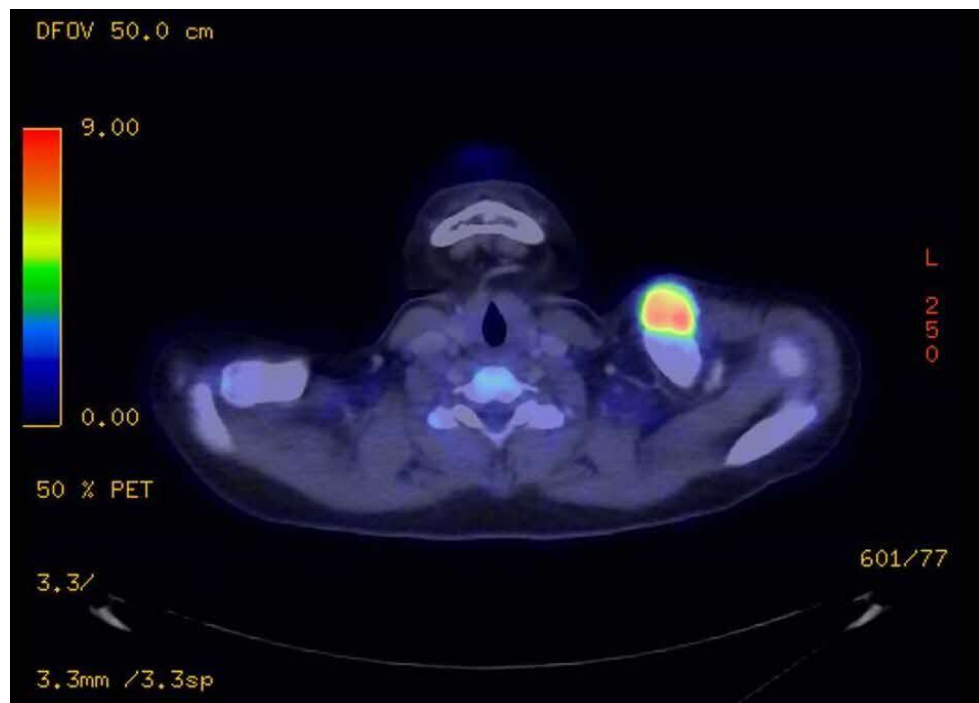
PET Scan showing a markedly FDG-avid bone forming lesion in the left clavicle.
